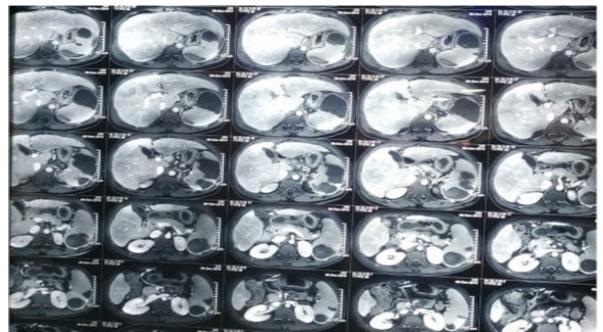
MRI whole abdomen showing Gallstones and Multiple splenic infarcts
